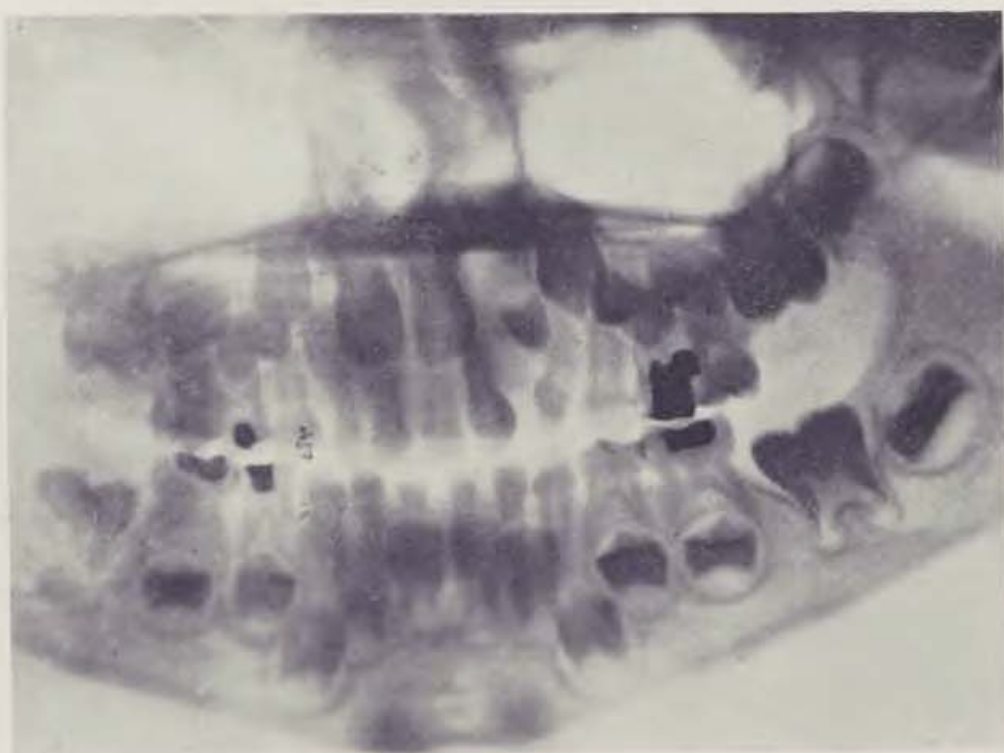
5 Patient J. K. with left-sided cleft lip and palate. Orthopantomograms at ages 4 and 5 and a half. The latter age picture shows the mesial migration of teeth within lateral segment
